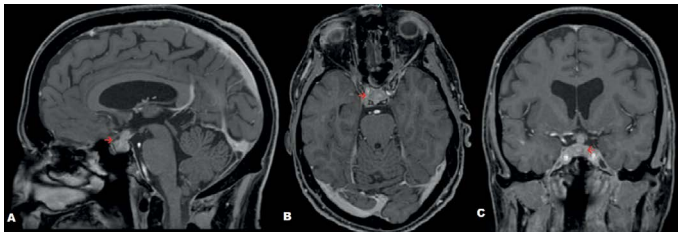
Contrast enhanced magnetic resonance imaging scans of sagittal (A), axial (B) and coronal (C) views. Arrows demonstrate mass-like enhancement of pituitary and pituitary stalk with marked suprasellar mass-like extension to the suprasellar cistern causing superior displacement and flattening of the optic chiasm
